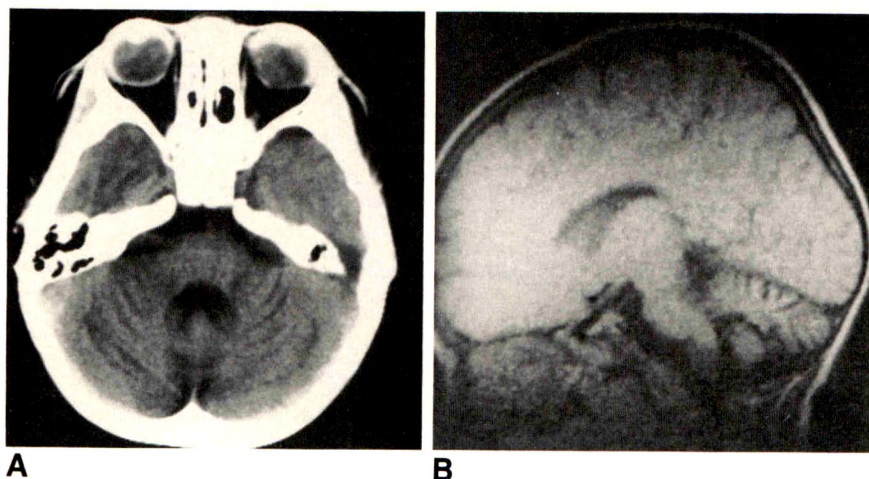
A and B, CT scan (A) of posterior fossa and sagittal MR image (B) obtained 8 months after treatment with high-dose cytosine arabinoside show prominent cerebellar sulci indicative of cerebellar atrophy. Signal intensity on MR image is normal.
